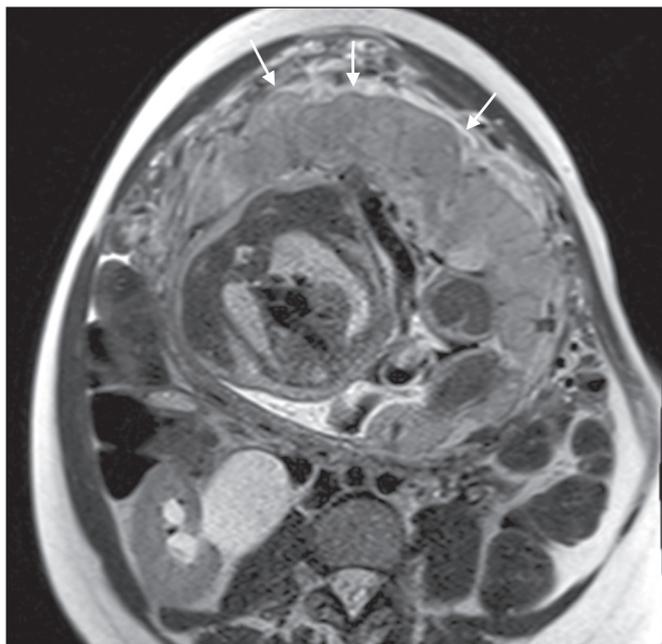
A 35-year-old patient with lobulated placenta (arrows). Coronal T2-weighted HASTE sequence.
